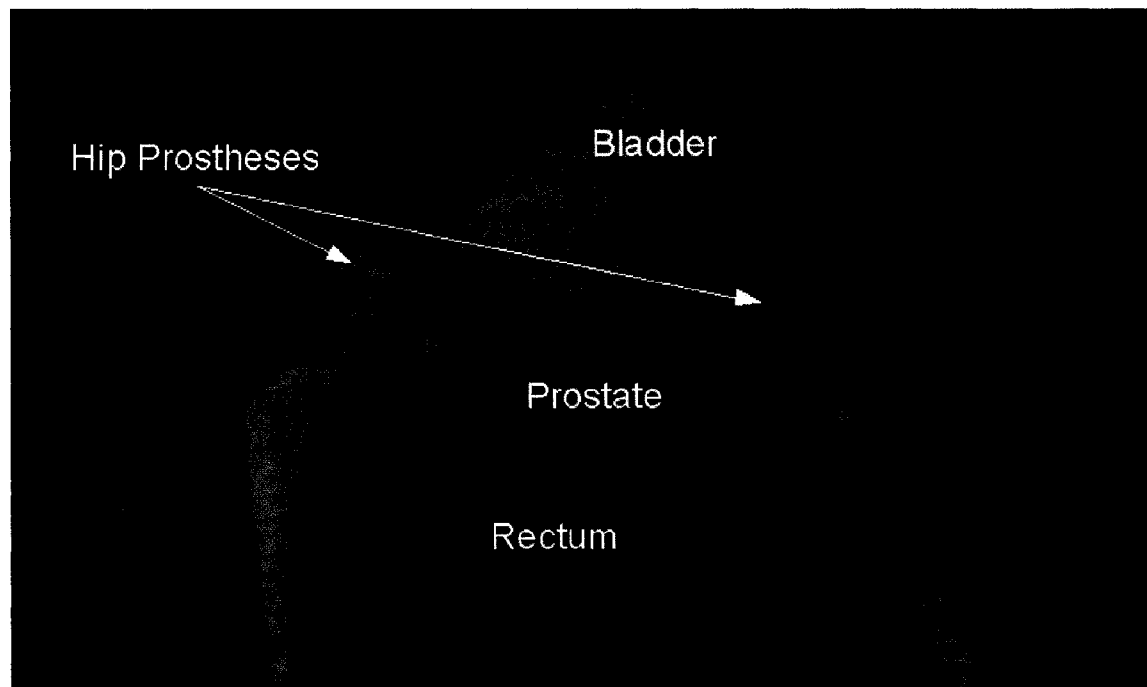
A 3D CT reconstruction of the critical structures surrounding the prostate.
